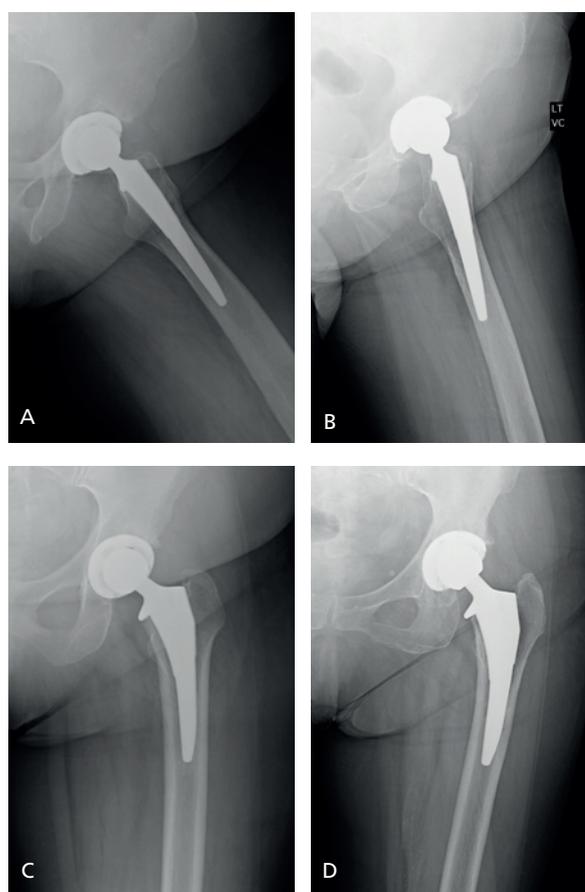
A/P and lateral X-Rays of different patients at four week and four month follow up. In some situations, the ACTIS Total Hip System may appear undersized in the A/P plane (Figures B,D). In these situations, use a lateral X-Ray to confirm size (Figures A,C).
